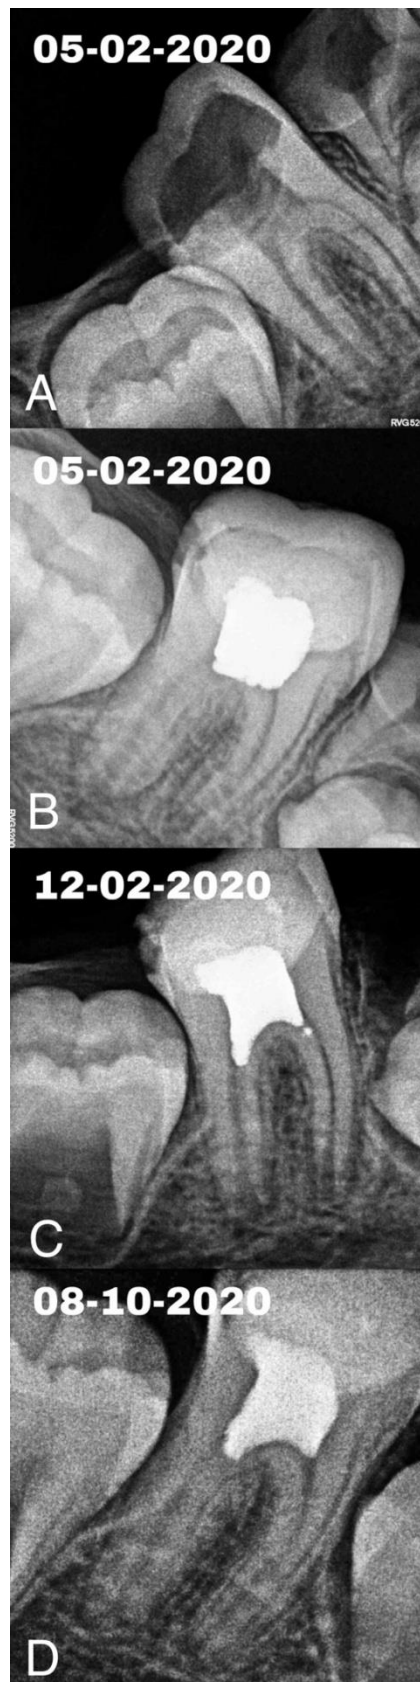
Preoperative and postoperative x-ray taken during 1st, 2nd and 3rd appointment
